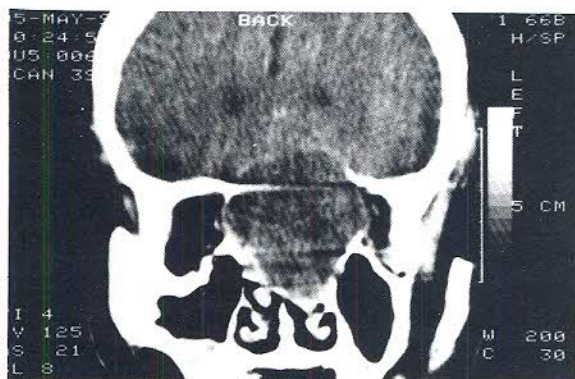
Case 1. CT scan (with IV contrast) taken preoperatively shows a mucocele involving the sphenoid and ethmoid sinuses and extending into the left orbit, anterior cranial fossa and nasal cavity.
